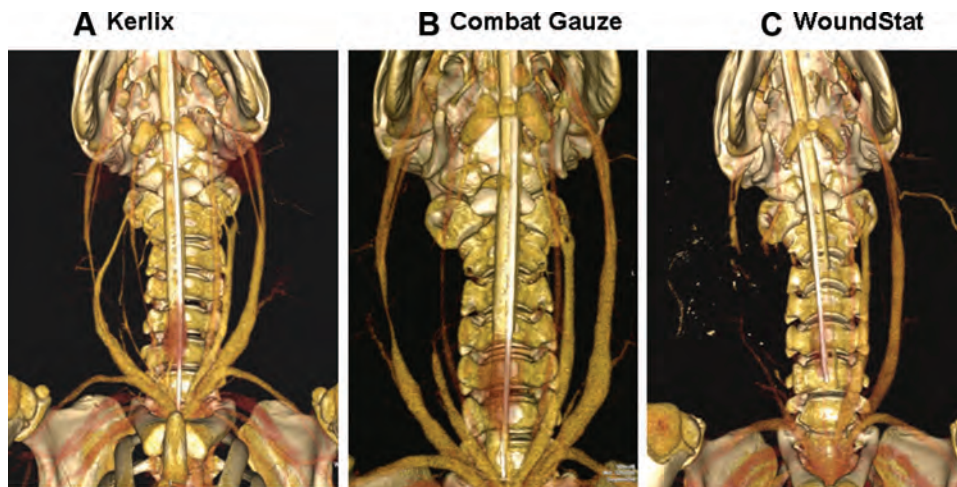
Typical CT images of blood flow through the external jugular veins 2 hours after reflow. Note the narrow blood flow (vasoconstriction) through the veins treated with KX or CG (A and B) and abolished flow in the vein treated with WS (C).
